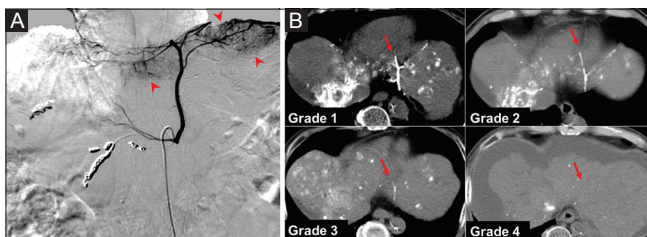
(A and B): (A) A 60-year-old-man underwent repeat hepatic arterial infusion chemotherapy (HAIC) for primary hepatocellular carcinoma (HCC). On follow-up, the left inferior phrenic artery (IPA) supplied the HCC of the left hepatic lobe (arrowheads). IPA was embolized with the NBCA-Lipiodol mixture to allow distribution of anticancer drugs. (B) Visual evaluation of residual Lipiodol. Residual Lipiodol was seen just after embolization with the NBCA-Lipiodol mixture (Grade 1). In follow-up CT, progression to Grade 2 required 62 days, Grade 3 required 120 days, and Grade 4 required 159 days after embolization. Residual Lipiodol was expected to gradually disappear (arrows)
